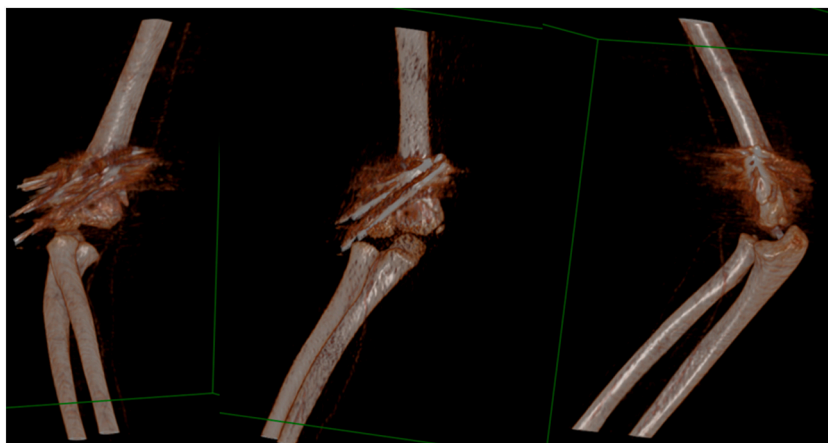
Elbow CT-scan with three-dimensional reconstruction. The three K-wire are present.
